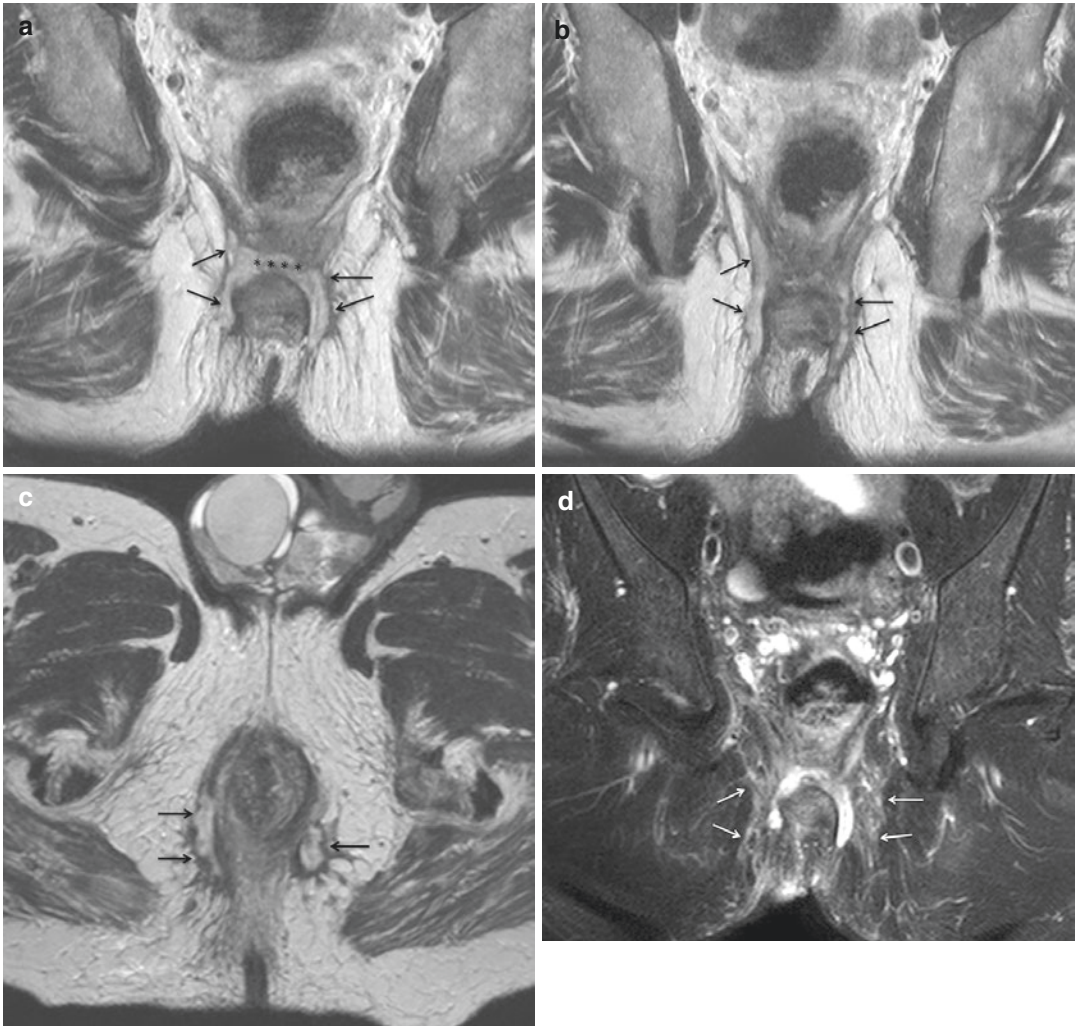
Complex perianal fistula. Coronal-oblique T2-weighted TSE images (a, b) and axial-oblique T2-weighted TSE image (c) show a horseshoe-like inter-sphincteric fistulous tract (asterisks in a), which extent
